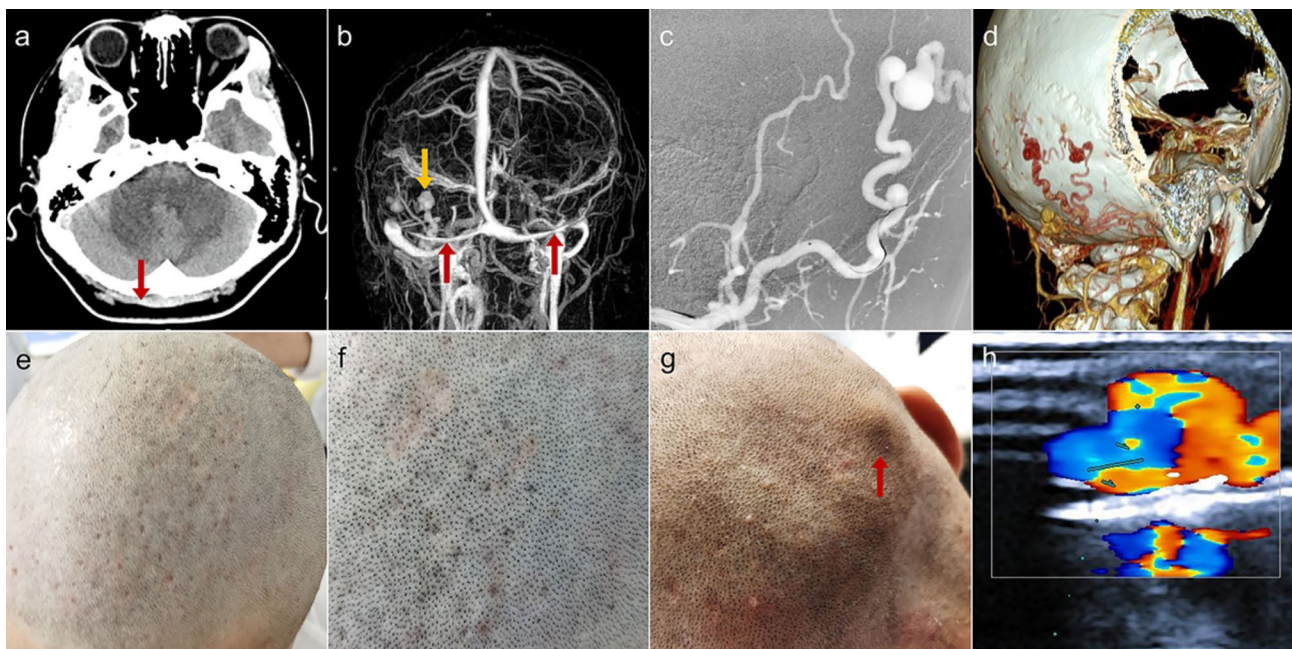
Imaging: Head CT (A) revealed multiple soft tissue densities under the scalp in both occipital regions, prominently on the right (red arrow); CE-MRV (B) showed slenderness of bilateral transverse sinus (red arrows) with abnormal vascular mass in the right occipital region (yellow arrow); a scalp AVF fed by the right occipital artery on DSA imaging (C) and abnormal vascular mass in the right occipital region on CTV imaging (D). Physical examination of the occiput after head-shaving revealed scalp swelling on the occipital cranium (E, F) and a small pulsating lump in the occipital scalp (G, red arrow). Ultrasound findings (H): Tortuous vascular mass measuring 9.6×8.8 mm, which showed significantly increased blood flow velocity at the proximal of the fistula with a “spicule-like” edge on the blood flow spectrum and mixed-frequency blood flow sound. At the distal end, there was a relative decrease in blood flow velocity and pulsatile index. Blood flow imaging of the deep side of the fistula revealed abnormal blood flow mixing in the intracranial venous sinuses
